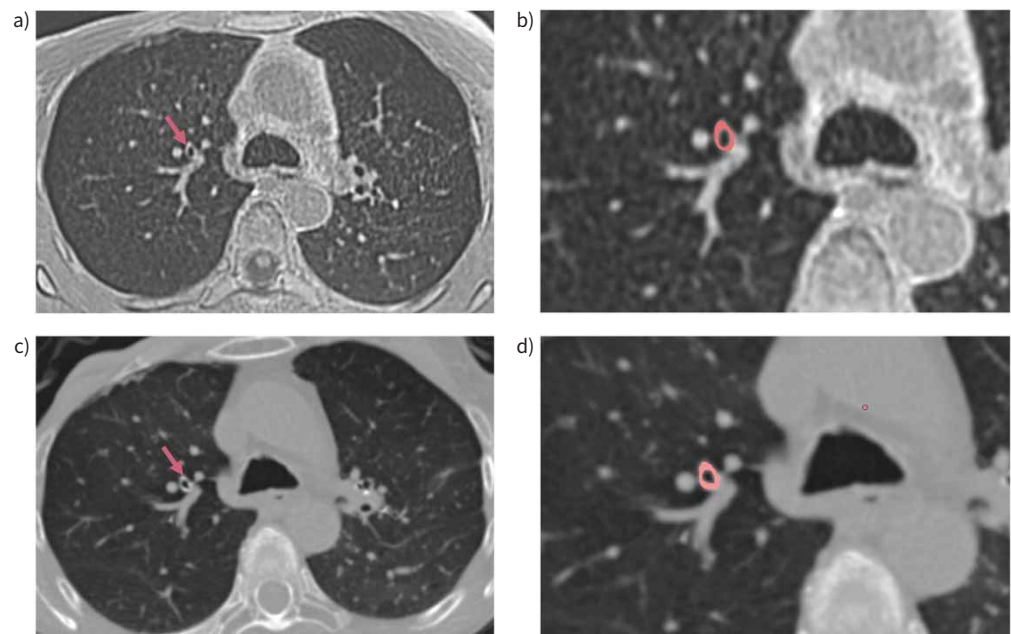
Representative lung images from a 59-year-old patient with severe asthma. Visualisation of wall area measurements of RB1 (right upper lobe) (red arrow) using magnetic resonance imaging with ultrashort echo time pulse sequence (a, b) or computed tomography (c, d).
